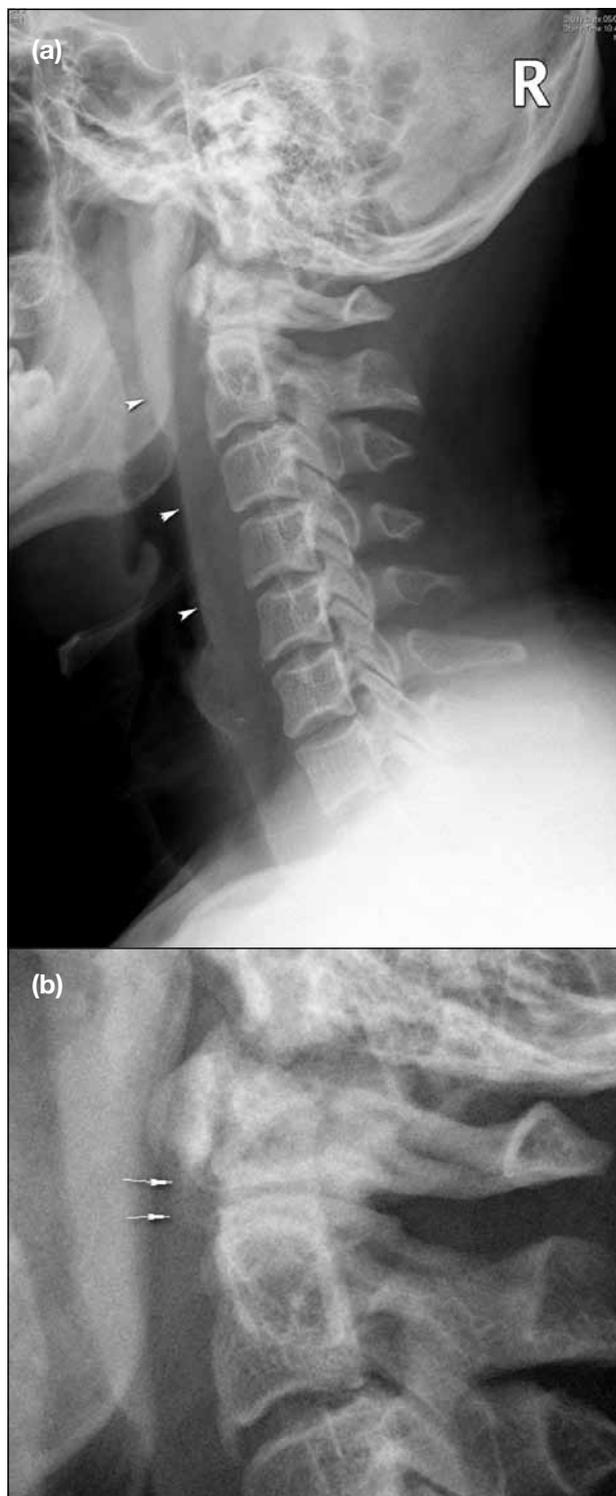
(a) A lateral cervical radiograph on admission shows prevertebral soft tissue swelling (arrowheads). (b) Calcifications inferior to the anterior arch of the C1 vertebra were very subtle (arrows).
